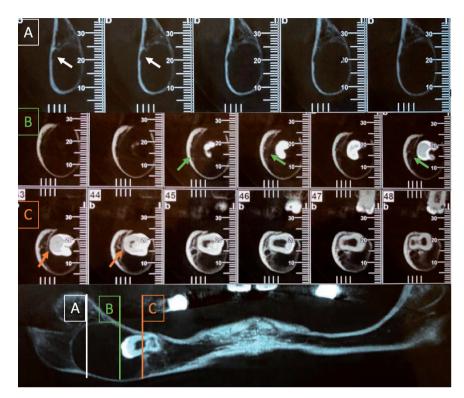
Cone beam computed tomography of the mandible:
